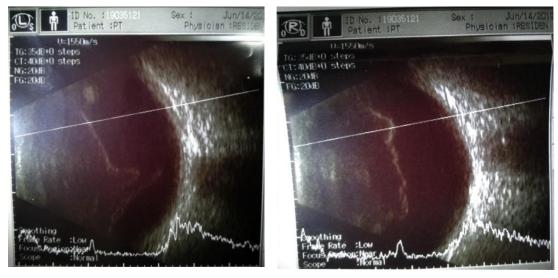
Ultrasound of both eyes shows the vitreous opacity
